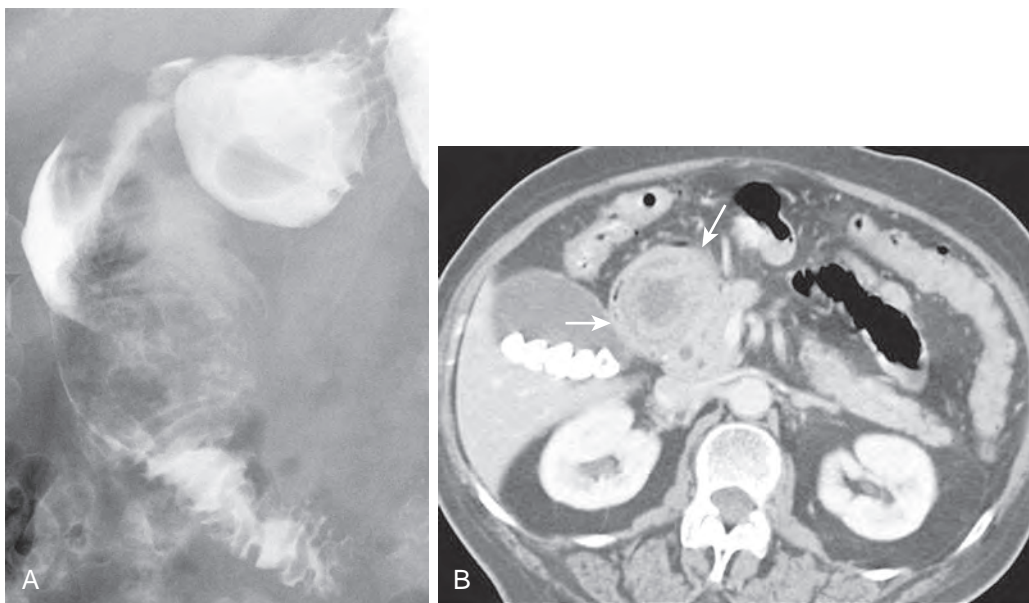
Benign GIST with gastroduodenal intussusception. A. A large, smooth mass extends from the duodenal bulb into the descending duodenum. Note the characteristic coiled spring appearance of an intussusception and foreshortening of the distal antrum. This patient had a benign GIST in the stomach that prolapsed through the pylorus, acting as the lead point for this gastroduodenal intussusception. B. CT scan shows the target sign of an intussusception with concentric rings (arrows) in the descending duodenum.
